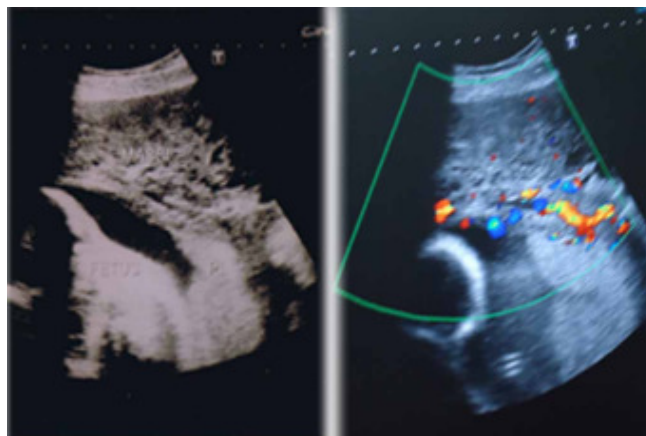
A & B . Ultrasoun (A) Showing Complex intra placental mass with solid and cystic areas. Colour Doppler (B) Showing intense vascularity in the mass suggestive of chorioangioma
